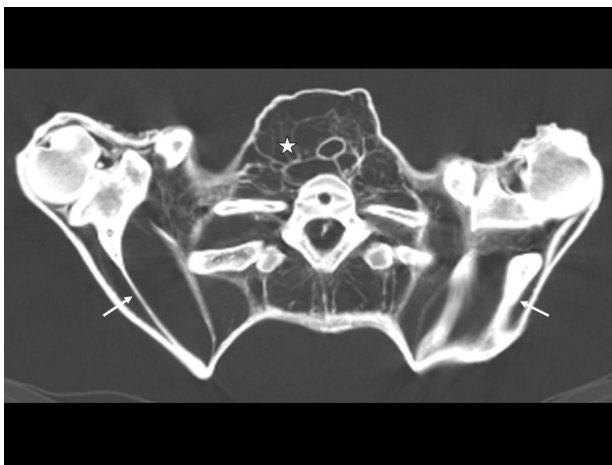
Axial CT image of the lower neck region and shoulder joints of unknown man E. Scapulae are shifted to the lateral side (arrows), and soft tissues are inflated because of gas formation (star)
